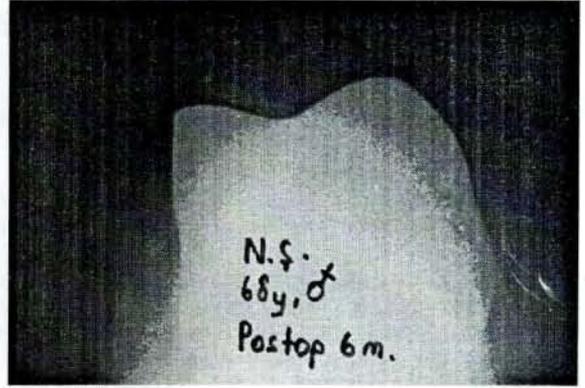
c: Postoperative 6th month tangential X-ray
